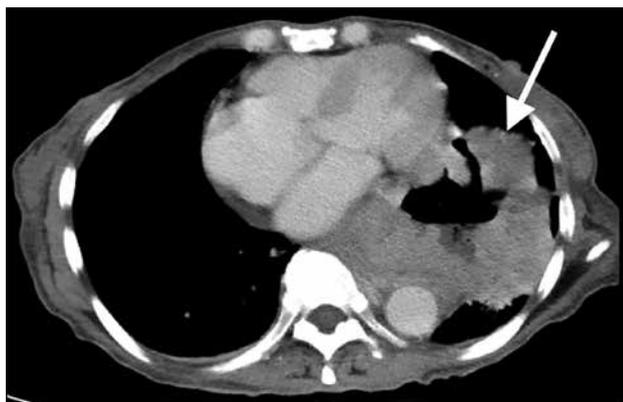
Oesophageal gastrointestinal stromal tumour in a 65-year-old woman. Contrast-enhanced computed tomography showing a large heterogeneously enhancing mass at the distal oesophagus (arrow). Internal air-fluid level may represent necrotic component communicating with the oesophageal lumen.
